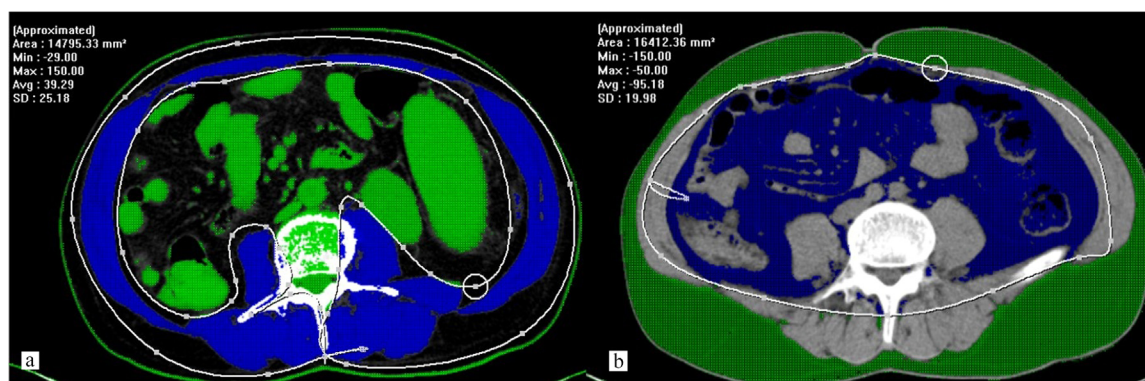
Abdominal CT images of a cirrhotic male patient with sarcopenic obesity. A threshold range of -29 to 150 HU was used to define skeletal muscle and -150 to -50 HU to define visceral adipose tissue. Skeletal muscle area 147 cm^2 , height 1.82 m^2 , skeletal muscle index $44.4 \text{ cm}^2/\text{m}^2$, visceral adipose tissue 164 cm^2 .
